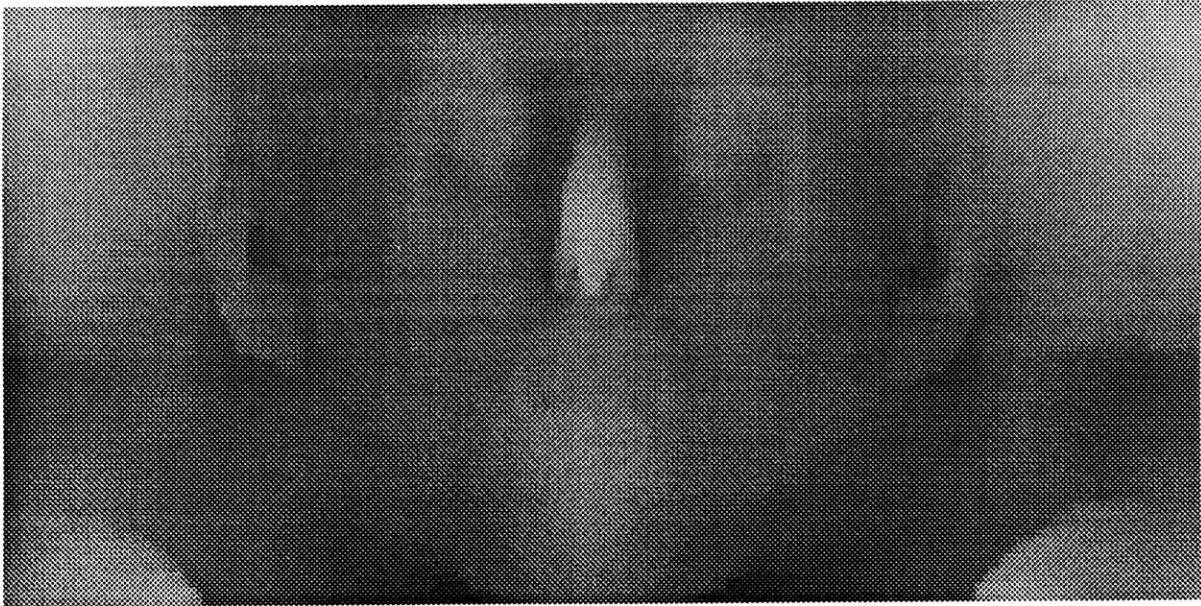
Skin surface range map derived from CT scan.
